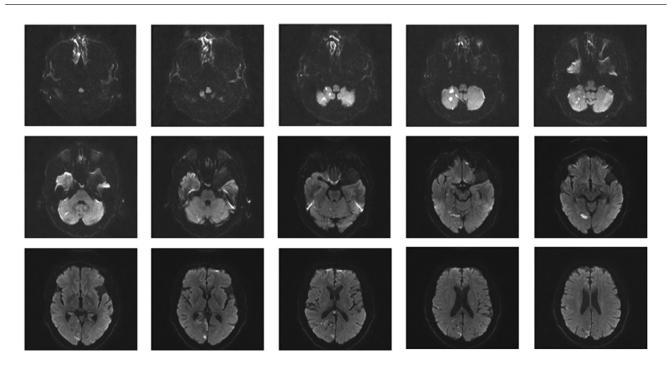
MRI Brain demonstrating multifocal acute infarcts on diffusion weighted sequences in the right cerebellar hemisphere, right occipital cortex, right parietal cortex and corpus callosum.
